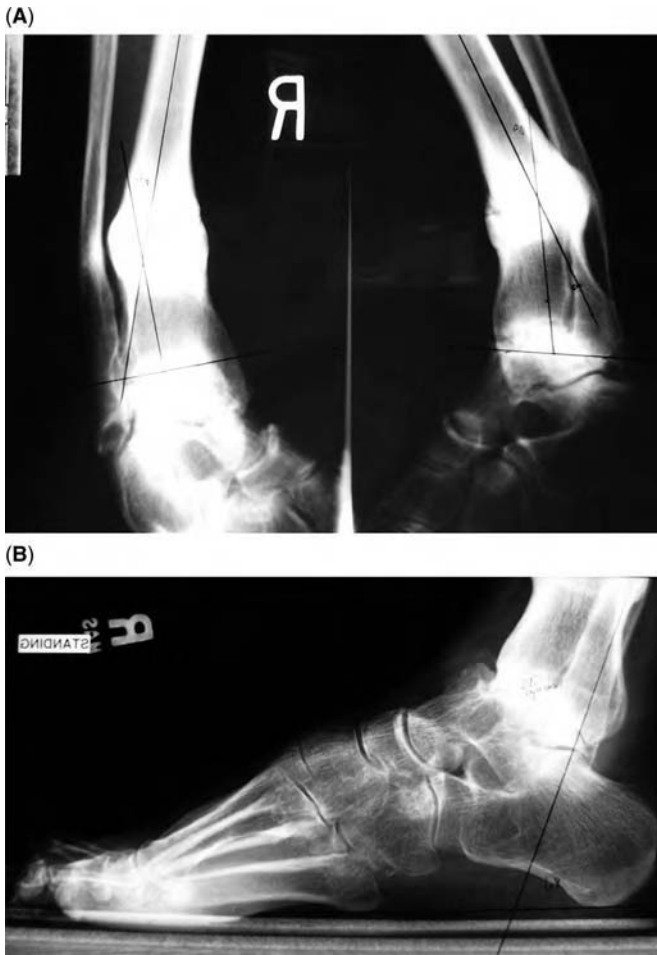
(A) Anteroposterior and lateral radiographs showing a patient with a varus, recurvatum malunion with associated ankle arthritis. (B) Lateral X-ray of the ankle showing the advanced ankle arthrosis combined with equines contracture of the ankle.
